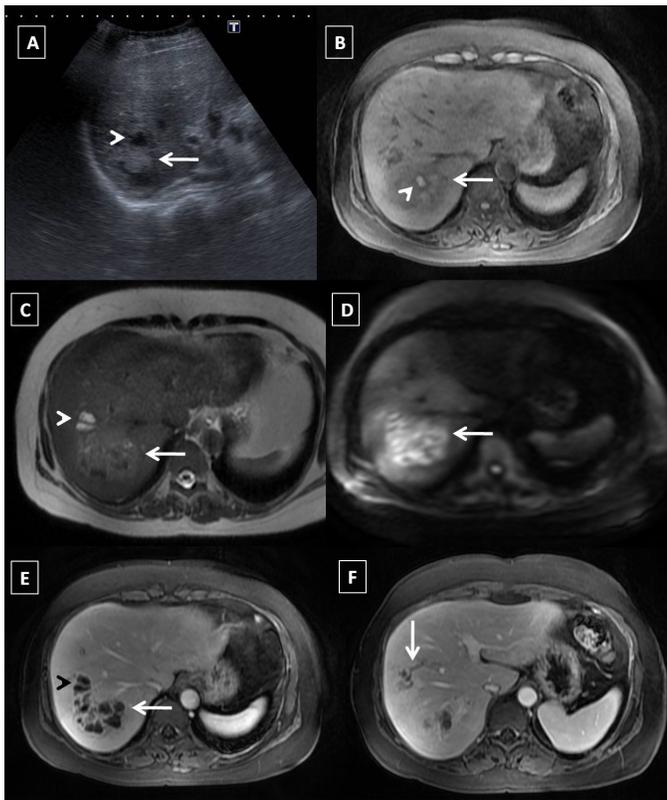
A 55-year old female came with fever and right upper quadrant pain. (A) Gray-scale ultrasound image showing heterogeneous, predominantly hyperechoic mass lesion in the right lobe of liver (arrow) with few cystic areas (arrowhead). (B) T1-weighted axial MR image showing a hypointense mass (arrow) with few hyperintense foci (arrowhead). (C) T2-weighted axial MR image demonstrating a hyperintense mass (arrow) with cigar-shaped cystic lesions within (arrowheads). (D) The lesion shows diffusion restriction (arrow). (E) Peripheral enhancement is seen within this conglomerate mass (arrow). (F) Segmental thrombosis of segment-V portal venous radicle is seen secondary to the lesions (arrow).
